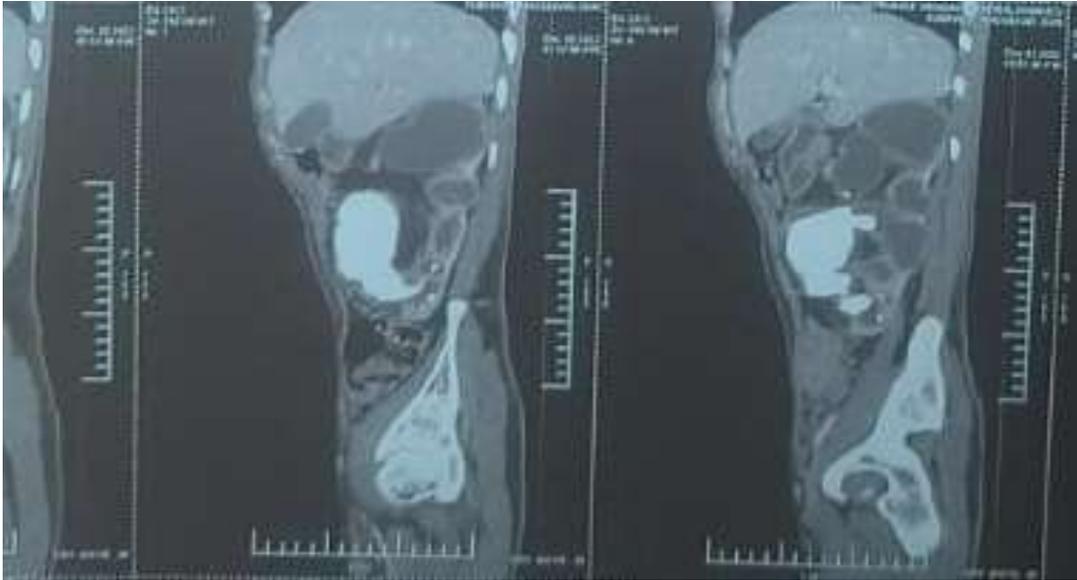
Sagittal section films of CT urography showing the Right aided gigantic calculus with gross hydronephrosis of the right kidney.
